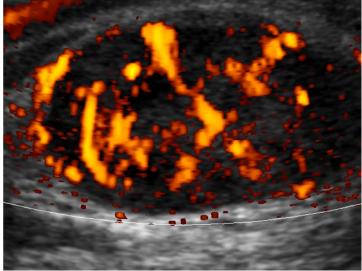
Strong suspicion of lymph node malignoma with pathological vessels; right inguinal sections (with so-called power mode sonography)
